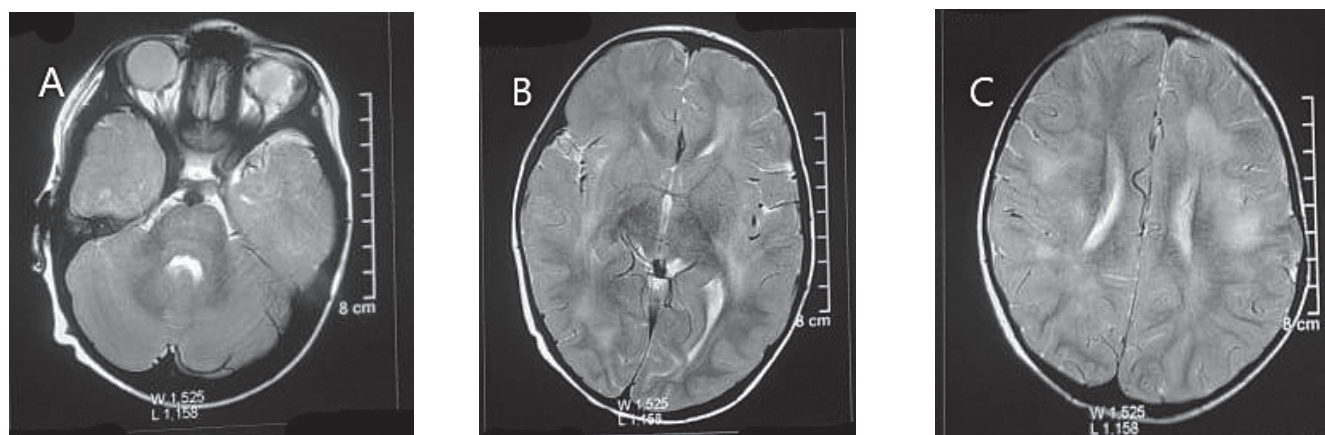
MRI brain axial T2 images - Multifocal hyperintensities in pons (A) and cerebral white matter (B,C).
